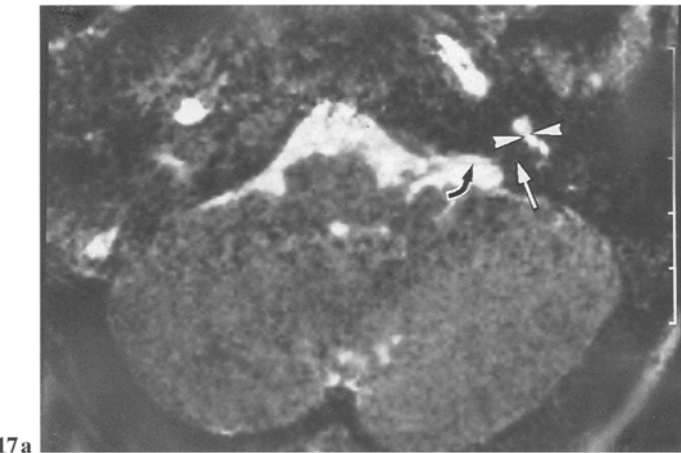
A 37-year-old man referred for a bilateral profound SNHL. Thin T2WI MRI depicts bilaterally a large endolymphatic duct (*arrows*). Associated right vestibular dilatation (*arrowhead*): enlargement of the endolymphatic duct and of the vestibule
